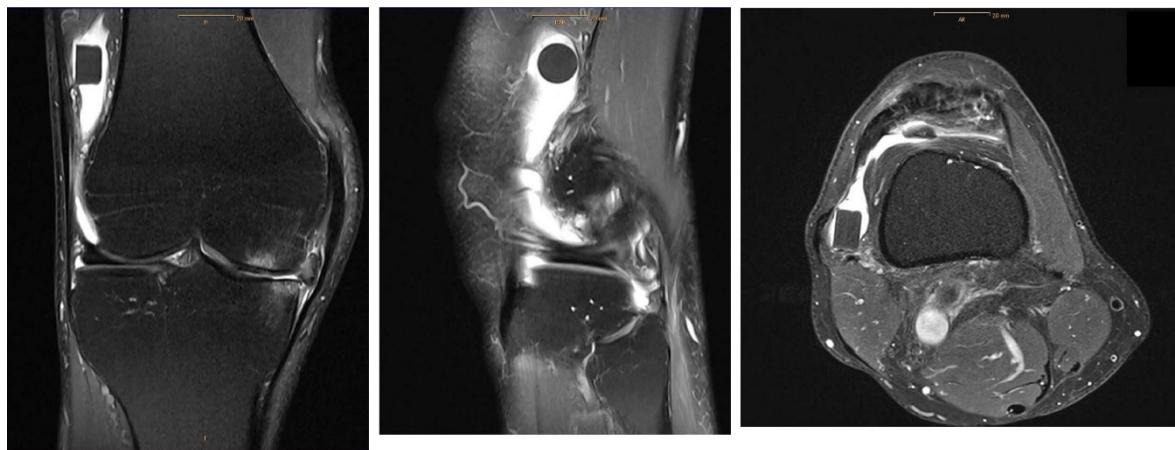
Preoperative MR imaging of lesion and foreign body.
